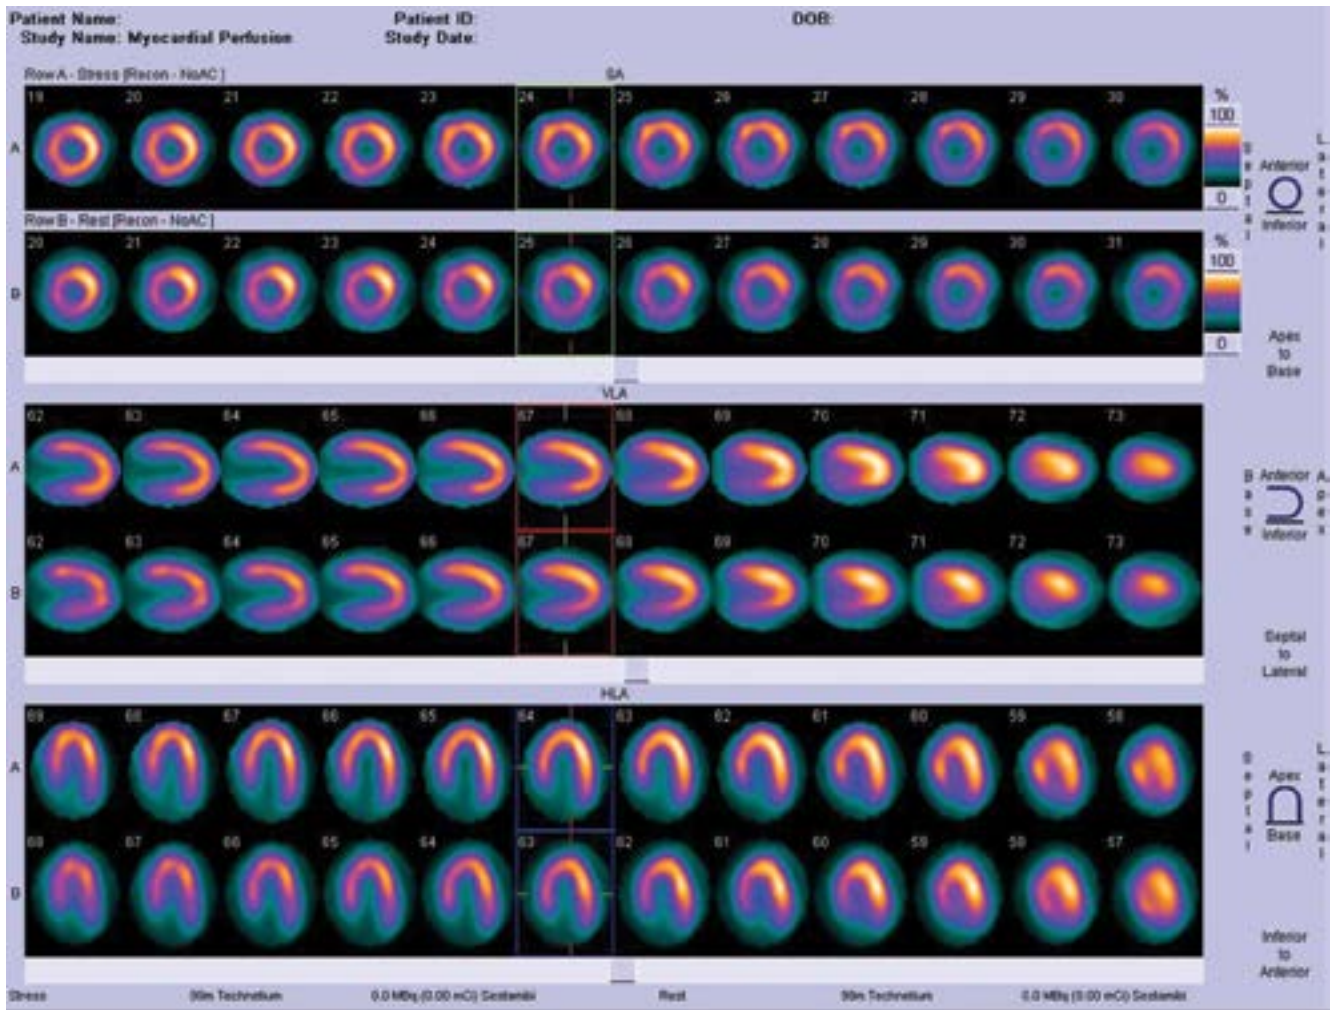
MIBI SPECT after 1 year
